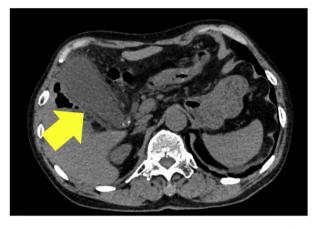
Abdominal computed tomography showed thickening of the gallbladder wall (arrow) and surrounding inflammation.
